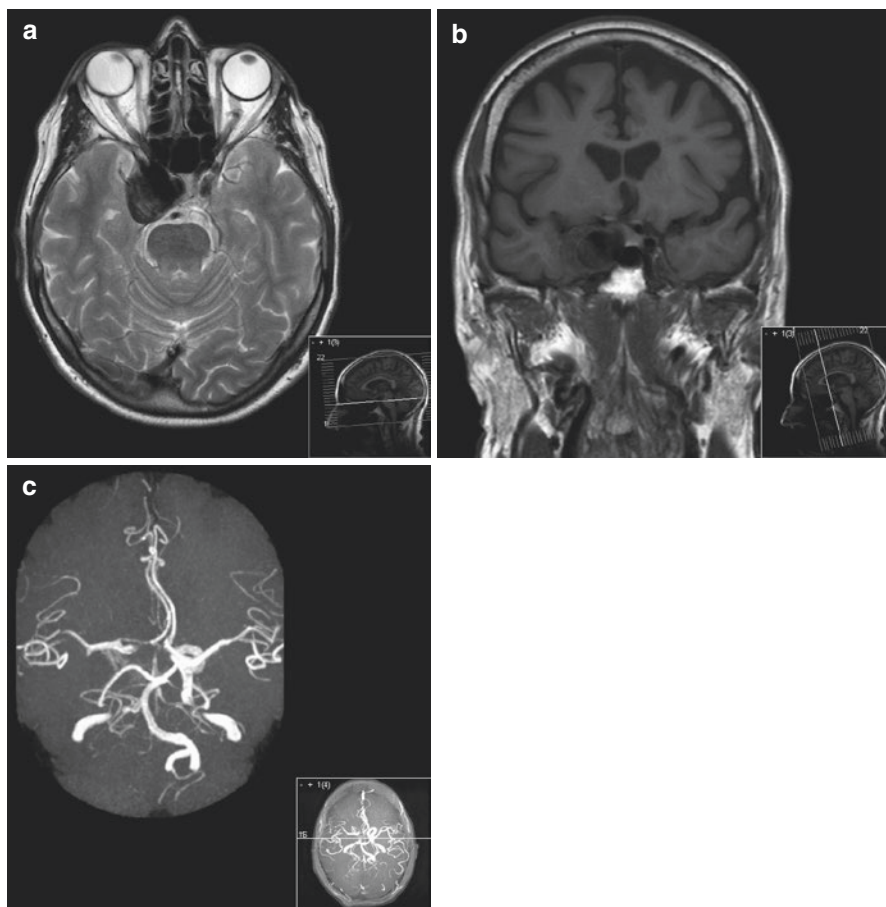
MRI of orbits showing a large mass centered on the right cavernous sinus which obliterates Meckel's cave. The area of abnormality shows reduced signal on the T2 weighted sequences (a), with concentric mild T1 shortening in the lateral aspect in keeping with partial thrombosis within a cavernous segment internal carotid artery aneurysm (b). The intracranial MRA (c) shows some disturbance of signal and likely underscores the true patent lumen of the aneurysm
